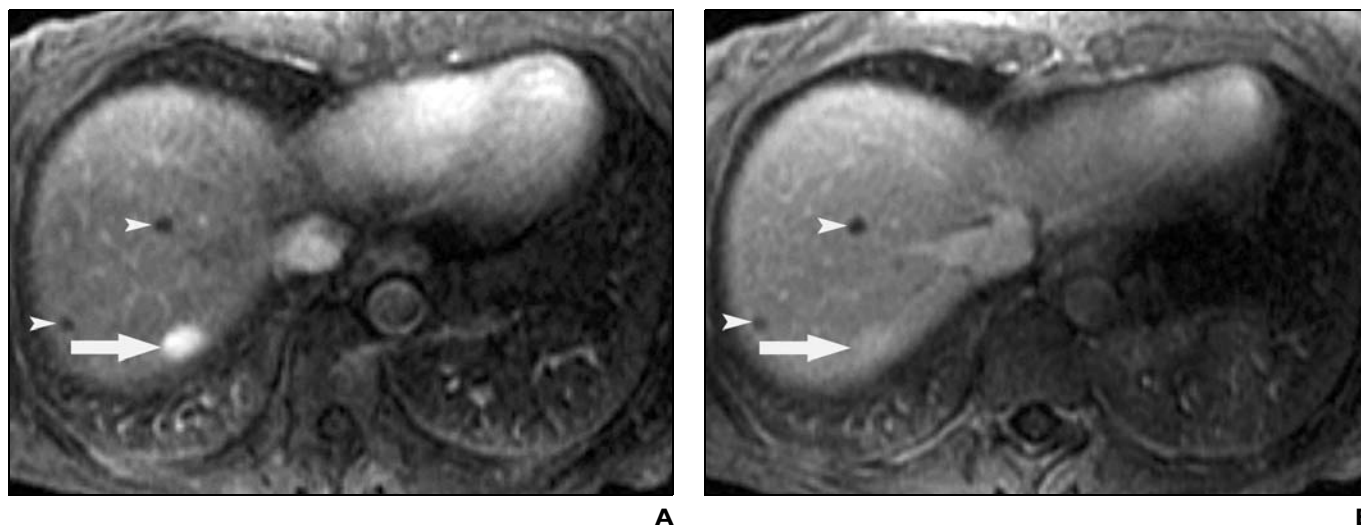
78-year-old woman with small-bowel gastrointestinal stromal tumor. A, Axial breath-hold 3D fat-suppressed gradient-echo MRI of liver with gadolinium shows bright homogenous enhancement of metastasis (arrow) in late arterial phase. Smaller hypovascular metastases are also evident (arrowheads). B, In venous phase, MRI of large metastasis shows complete washout of contrast material (arrow). Smaller hypovascular metastases are also evident (arrowheads).
